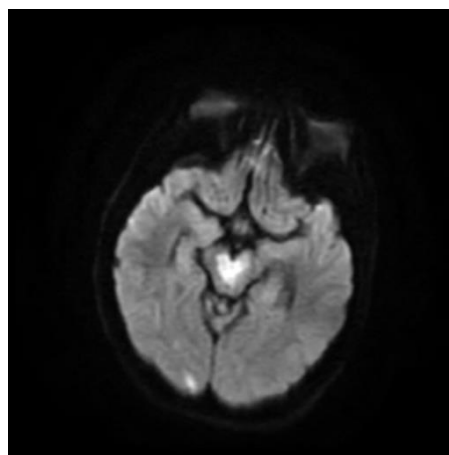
Axial diffusion-weighted MRI showing acute bilateral paramedian infarction of the rostral mesencephalon. Hyperintense lesions are visible within the dorsal midbrain tegmentum, corresponding to ischemic involvement of the oculomotor nuclear complex
